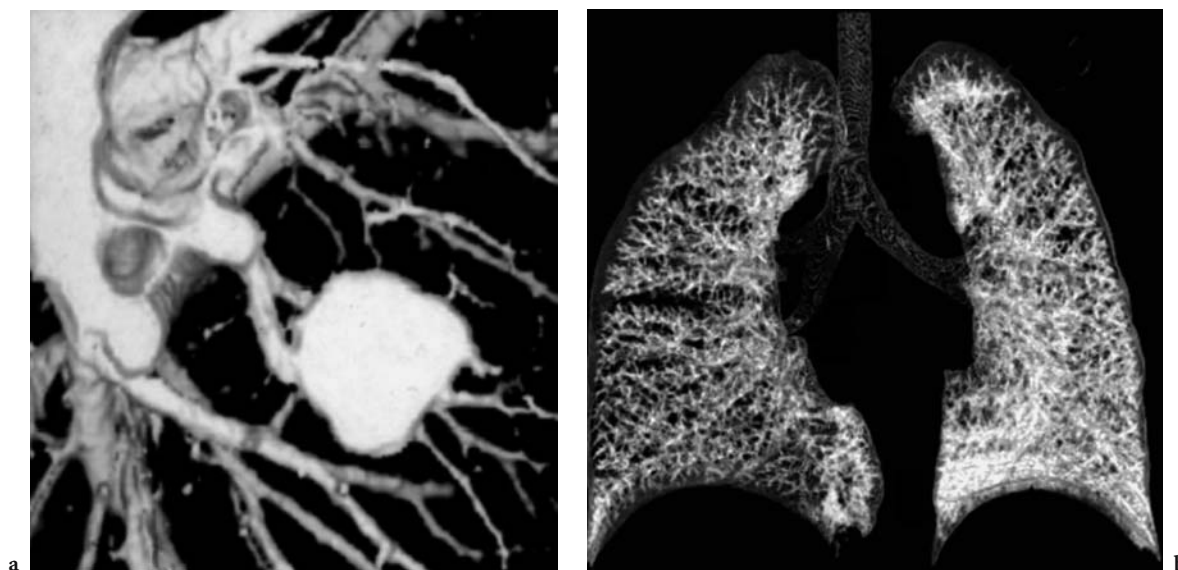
Spiral CT has made tremendous progress within approximately one decade. a The first scans of the thorax in 1989 were taken with single-row scanners at 10-mm collimation. b In 2001, 16-slice scanning at sub-millimeter collimation and with isotropic spatial resolution became available
